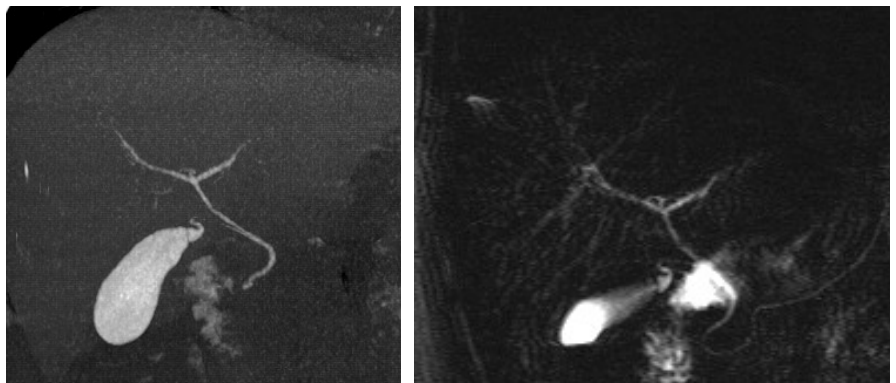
Corresponding biliary imaging (CT left, MR right) shows a trifurcation at the upper biliary confluent. In this case MRC and ceMDCT-CA performed equally well.
